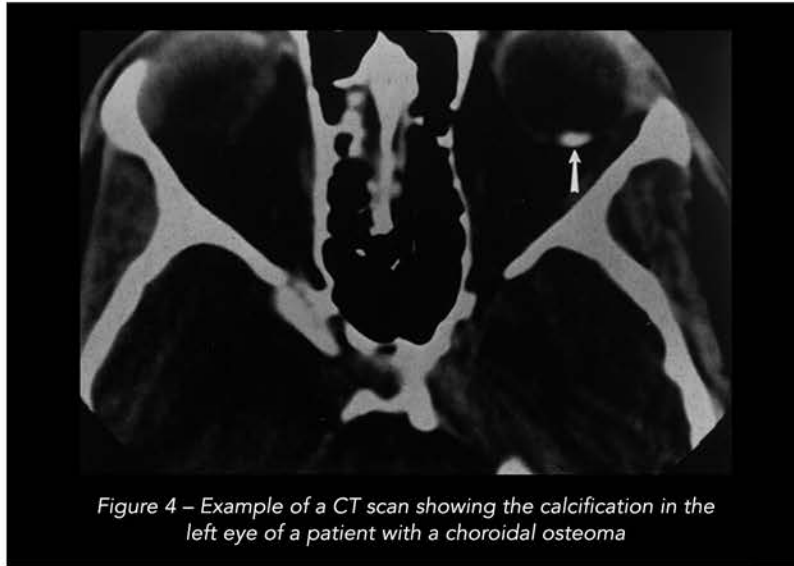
Example of a CT scan showing the calcification in the left eye of a patient with a choroidal osteoma
